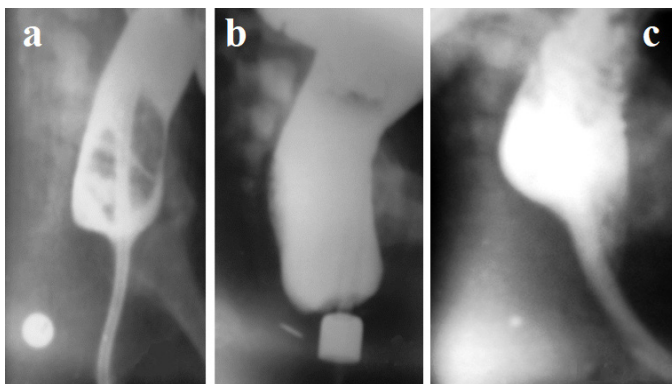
The radiographs of the same girl with vestibular fistula performed at different ages. (a) At the age of 3 months, the rectum was filled with barium through the catheter, conducted through the fistula. A pushpin is located near the anal dimple. The distal intestine, with a length equal to the length of the normal anal canal, constantly contracted around the catheter, preventing leakage of barium. (b) At the age of 9 months, during a barium enema, the wide opening of the anal canal occurred. The distance from the pushpin to the distal wall of the open anal canal equals 4 mm. Barium does not penetrate outward, since the tip of the enema occluded the narrow and rigid ectopic anus. The true diameter of the marker on the enema tip is 1.6 cm. The width of the rectum is 4.3 cm (the maximum rate for children 1-3 years is 3.7 cm). Conclusion: Ano-vestibular ectopy, megarectum. The diastasis between the anal canal and anal dimple is (4 mm), which corresponds to the thickness of the skin and subcutaneous tissue. (c) Barium was injected into the rectum through an intubation tube (no: 8), passed through the vestibular fistula. The penetration of barium into the upper part of the anal canal in front of the intubation tube is determined. The posterior wall of the anal canal is pressed against the tube of the contracted PRM. The contraction of the PRM and EAS provide normal liquid barium retention. This is a typical X-ray picture of a rectoanal inhibitory reflex
